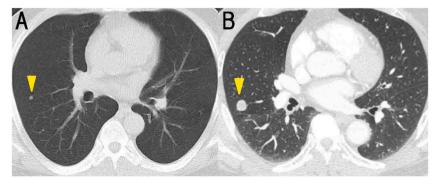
Chest computed tomography shows (A) A nodule located in the right middle lobe measuring  $3 \times 3$ mm in size with a smooth margin. (arrow) B) A nodule was  $13 \times 13$ mm in size, twelve years later. (arrow).
